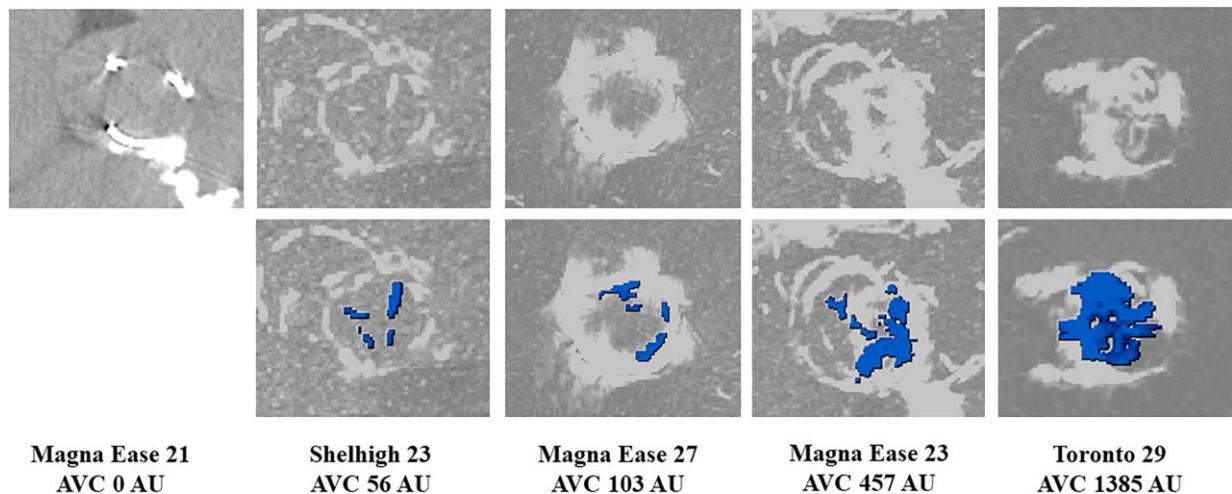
Measurement method of AVC with superimposition of different CT scan slices and calcifications layers from a normal to a severely calcified bioprosthetic valve. AVC, aortic valve calcification.
